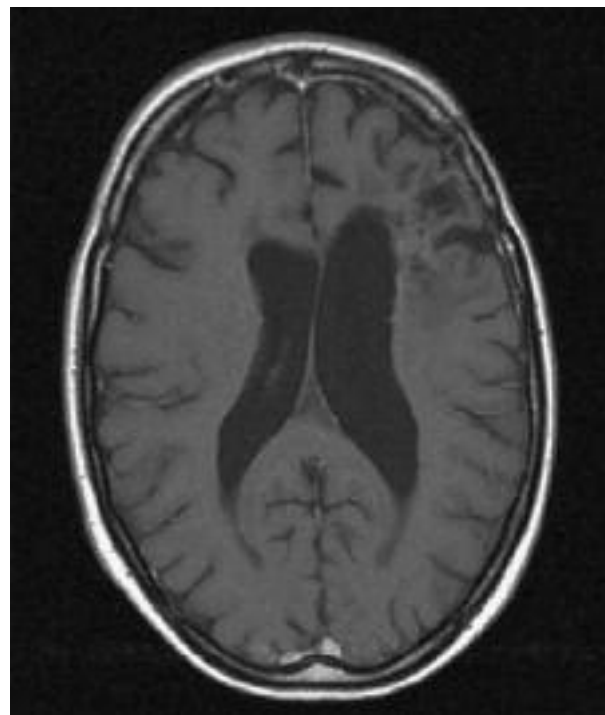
T1 weighted MRI with contrast injection 4 years after the start of temozolomide, showing no residual tumour mass.
